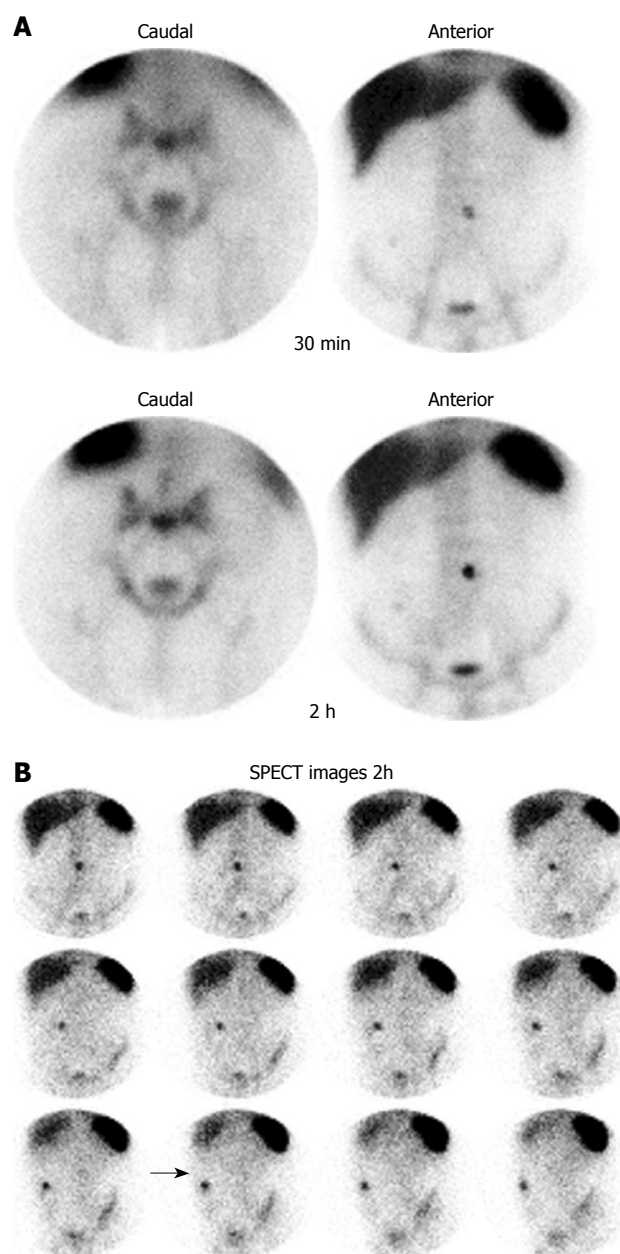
^{99m}Tc -HMPAO granulocyte scintigraphy of patient J.A.N., male, 44 years. A: Images obtained at 30 min and at 2 h after injection of the radiolabeled leukocytes, in the caudal and anterior projections; B: SPECT images 2 h after injection of the radiolabeled leukocytes. The arrow indicates the fistula region of the patient's abdomen.
